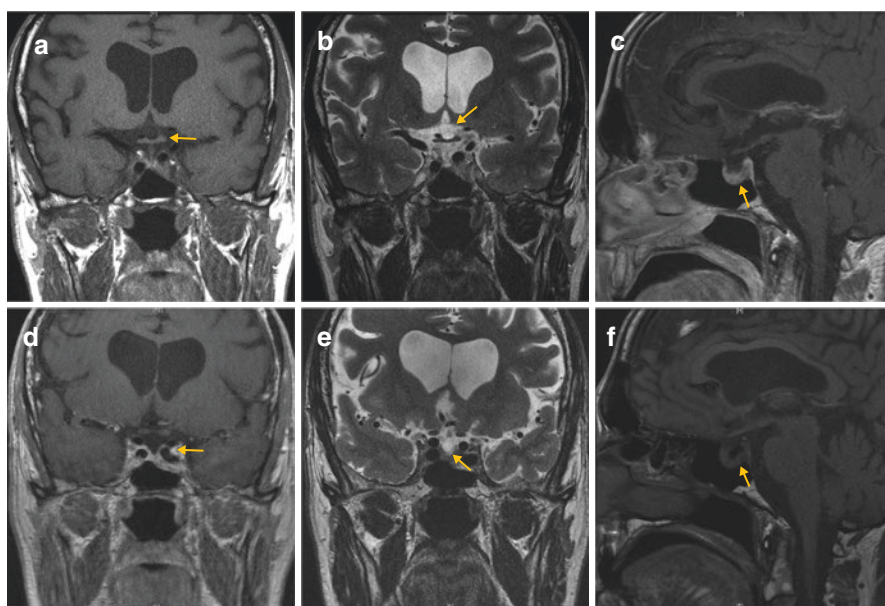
Pituitary magnetic resonance imaging (MRI) sections. Findings revealed a hypointense in T1-weighted images and isointense in T2-weighted images area of 14×5 mm on the left side of the pituitary, which extended to the left cavernous sinus and contacted the left internal carotid artery (indicated with small arrows). The rest of the pituitary was mildly displaced to the right, with mild stalk deviation. (a) Frontal T1-weighted after gadolinium; (b) frontal T2-weighted; and (c) sagittal T1-weighted after gadolinium at diagnosis. (d) Frontal T1-weighted after gadolinium; (e) frontal T2-weighted; and (f) sagittal T1-weighted after gadolinium after 6 months of medical treatment with long-acting lanreotide
